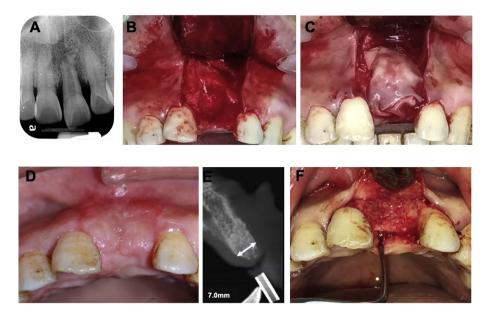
(A) Initial periapical x-ray showed external root resorption with periapical radiolucency around the root apex of tooth 21. (B) Clinical photograph demonstrated the totally buccal cortical plate dehiscence of tooth 21. (C) The bony defect was augmented with bone graft and platelet-rich fibrin membrane was used to cover the bone graft. (D) Clinical photograph 3 weeks after treatment. (E) After 3 months, the double-end arrow indicated that the horizontal width reached 7.0 mm on a cone beam computed tomography image. (F) Clinical photograph of re-entry for implantation after 3 months.
